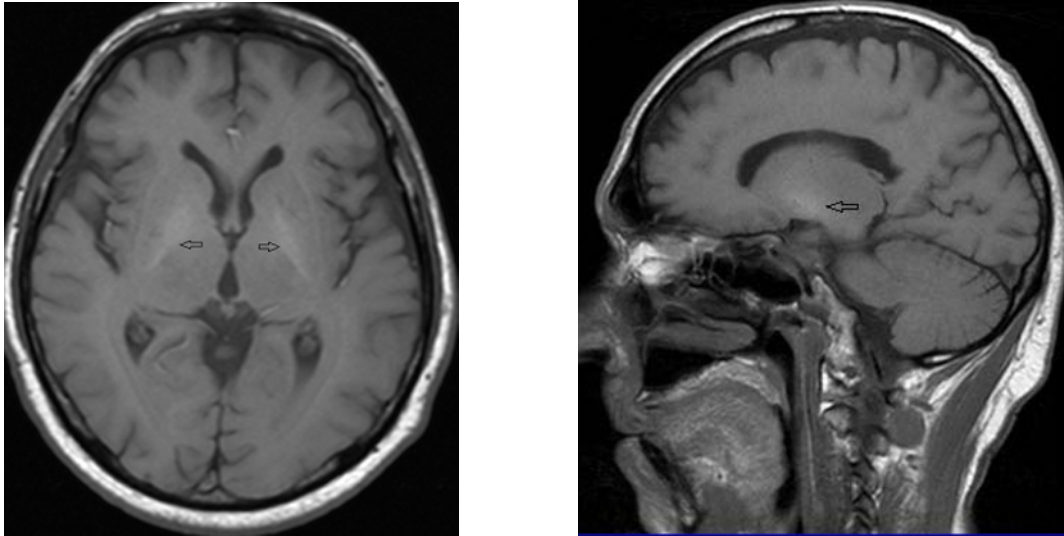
T1-weighted MRI image of brain (transversal section) showing bilateral hyperintensities in globus pallidus (arrows). 1b. T1-weighted MRI image of brain (sagittal section) showing hyperintensity in globus pallidus (arrow).
